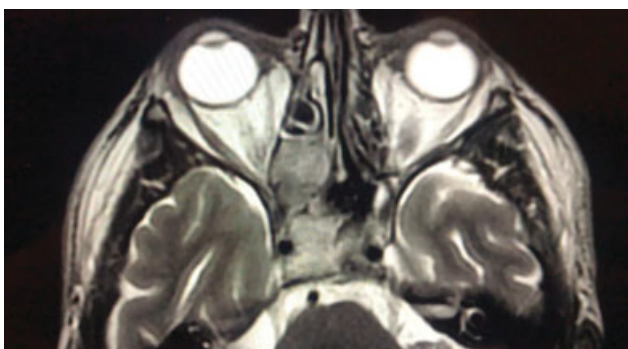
T2-weighted MRI showing lesion in the right nasal cavity with infiltration of the medial orbital wall and ethmoid bone with evidence of a sellar lesion involving the right carotid artery.
